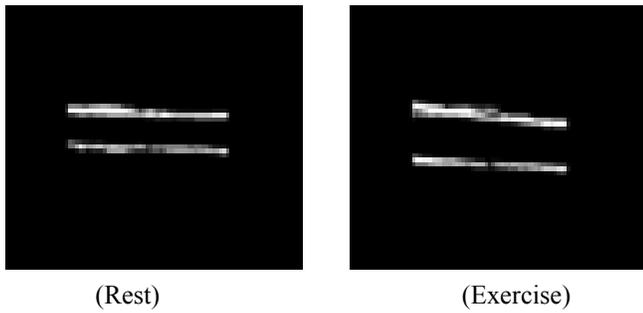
Segmented carotid artery wall ultrasound image
